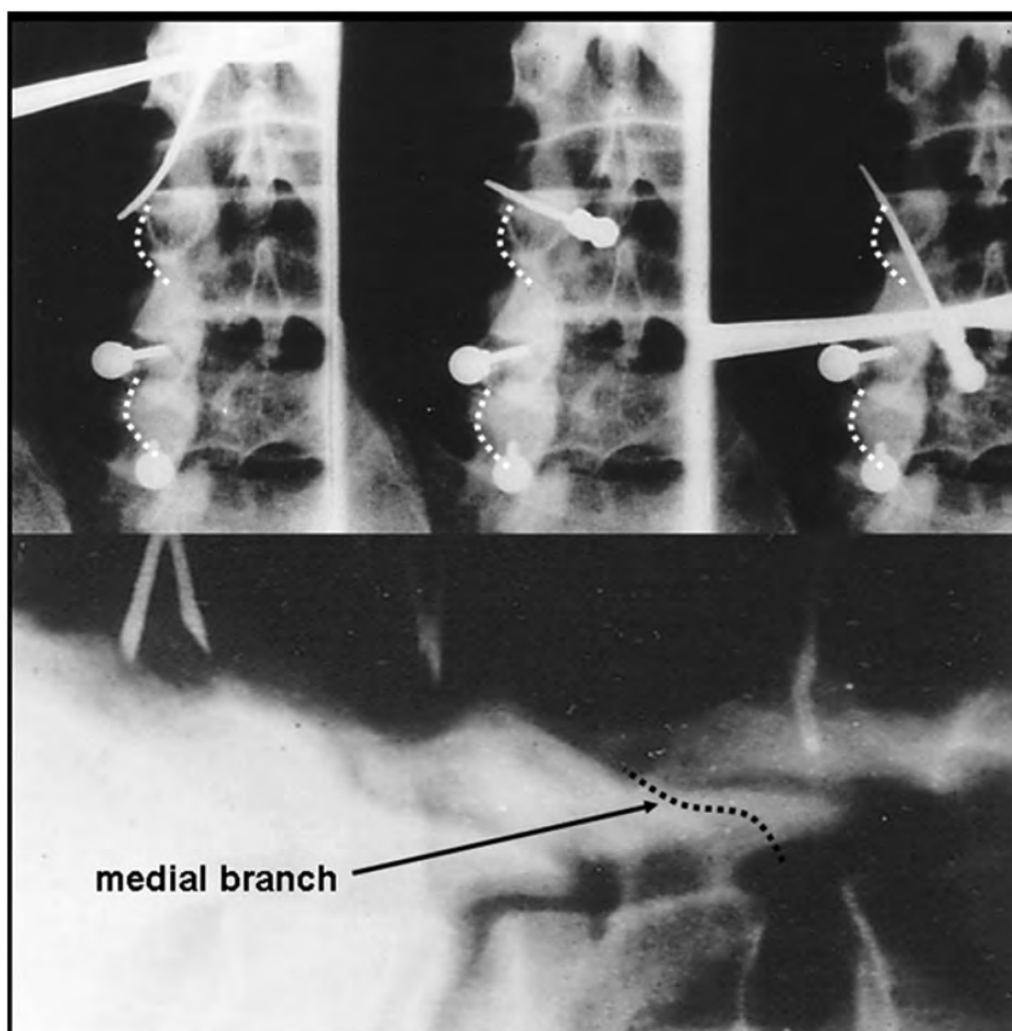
Copies of the radiographs of the Shealy technique (Figure 1), onto which the courses of the target medial branches have been drawn. At no placement of electrodes does the tip reach the nerve.
